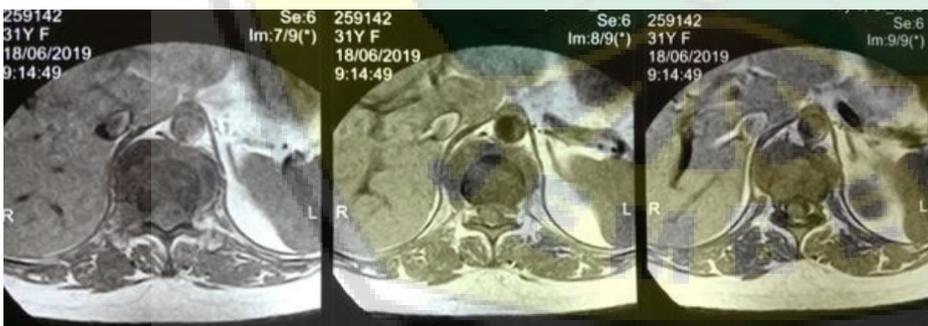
MRI of Thoracolumbal (coronal view).
